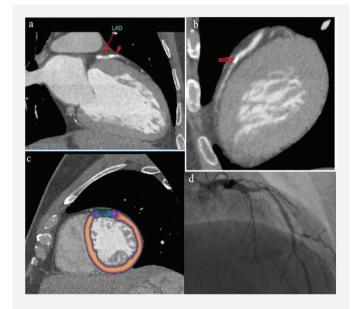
a, b) CCTA showed a calcified plaque in the proximal segment of the LAD artery and greater than 50% luminal narrowing in the distal segment of the LAD artery due to mixed plaque. c) First-pass CT-MPI without stress revealed a perfusion defect in the mid-anterior segment of the left ventricle. d) Invasive angiography shows greater than 50% luminal narrowing in the distal segment of the LAD artery
